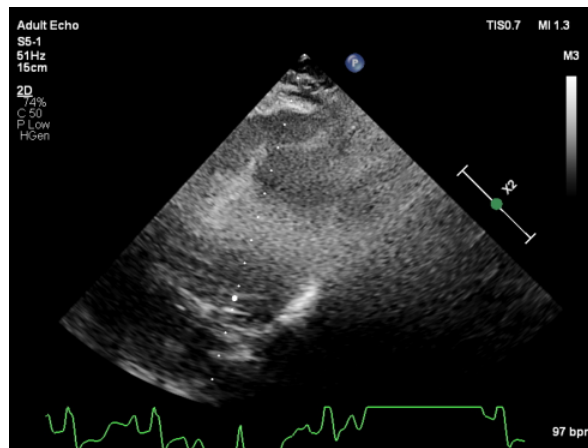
Example of an ECG_{us} signal within an ultrasound frame with a flatline artefact. These plateaus, which occur when the signal remains at its maximum value for a prolonged period, are treated as missing data in $ECG_{us,nan}$ to improve the quality of subsequent analyses.
